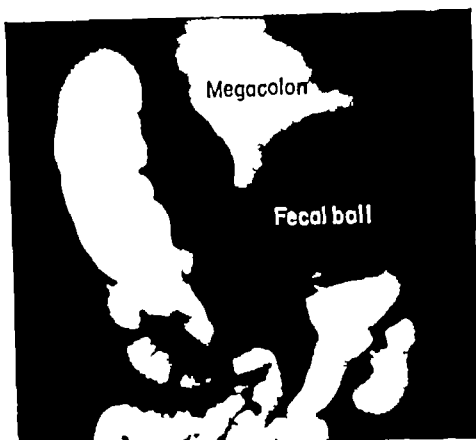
Roentgenogram of congenital megacolon (Hirschsprung's disease)
